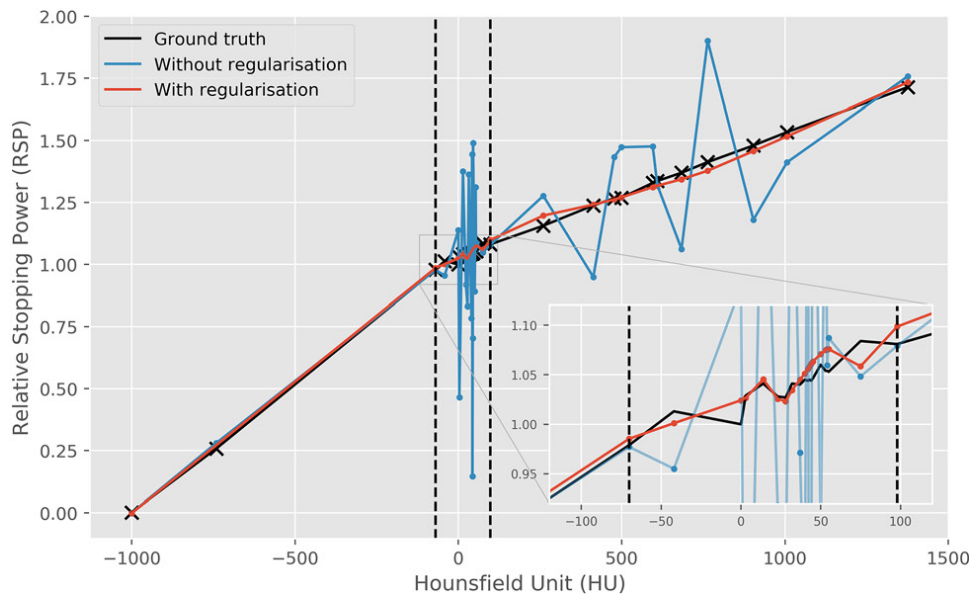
CT number to RSP conversion curve determined from a single proton radiography and an x-ray CT image, without (blue) and with (red) regularization). Figure re-printed from [J18].
